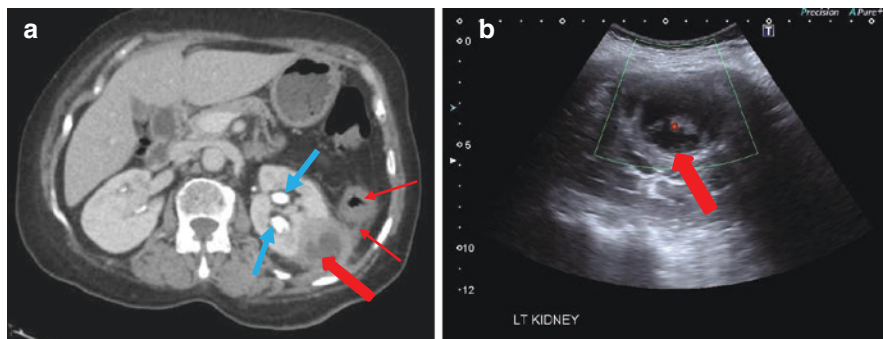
(a) Contrast enhanced axial CT scan slice. (b) Ultrasound left kidney. Findings: left kidney, on contrast CT (Image a) shows low attenuation necrotic focus with enhancing rim in keeping with a cortical renal abscess (thick red arrow). Note the peri-nephric stranding and reactive thickening of adjacent bowel loop (fine red arrows). Contrast is also noted within the left renal collecting system (blue arrows). Ultrasound (Image b) demonstrates a complex partly echogenic septated abscess (thick red arrow). Diagnostic aspirate performed under ultrasound (US), revealed culture positive mycobacterium tuberculosis. Image courtesy Dr Uday Patel, Consultant Radiologist, St George's Hospital NHS Trust, London, UK
